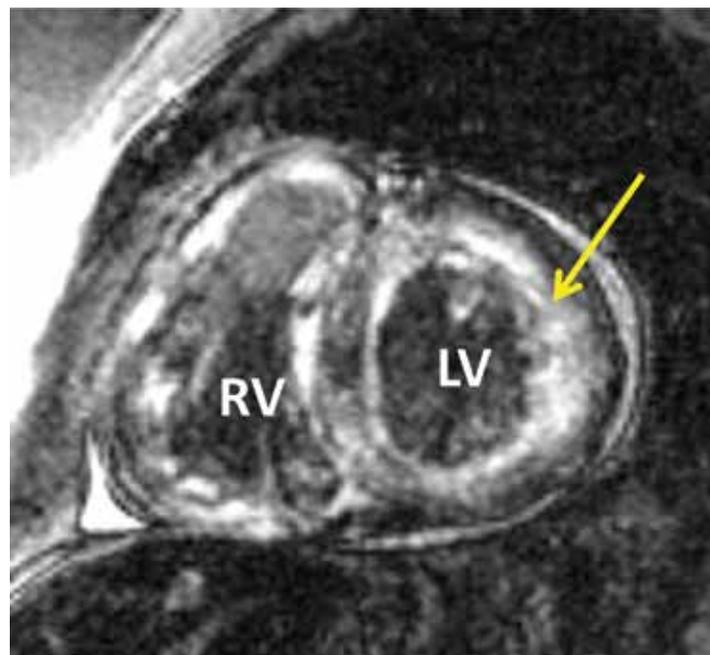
Delayed enhancement cardiovascular magnetic resonance imaging detection of cardiac amyloidosis. Short axis mid-ventricular view of the left (LV) and right ventricles (RV). Yellow arrows indicate global late gadolinium enhancement (transmural bright white pattern) that reflects extracellular expansion secondary to amyloid deposition in a patient with biopsy proven cardiac amyloidosis.
